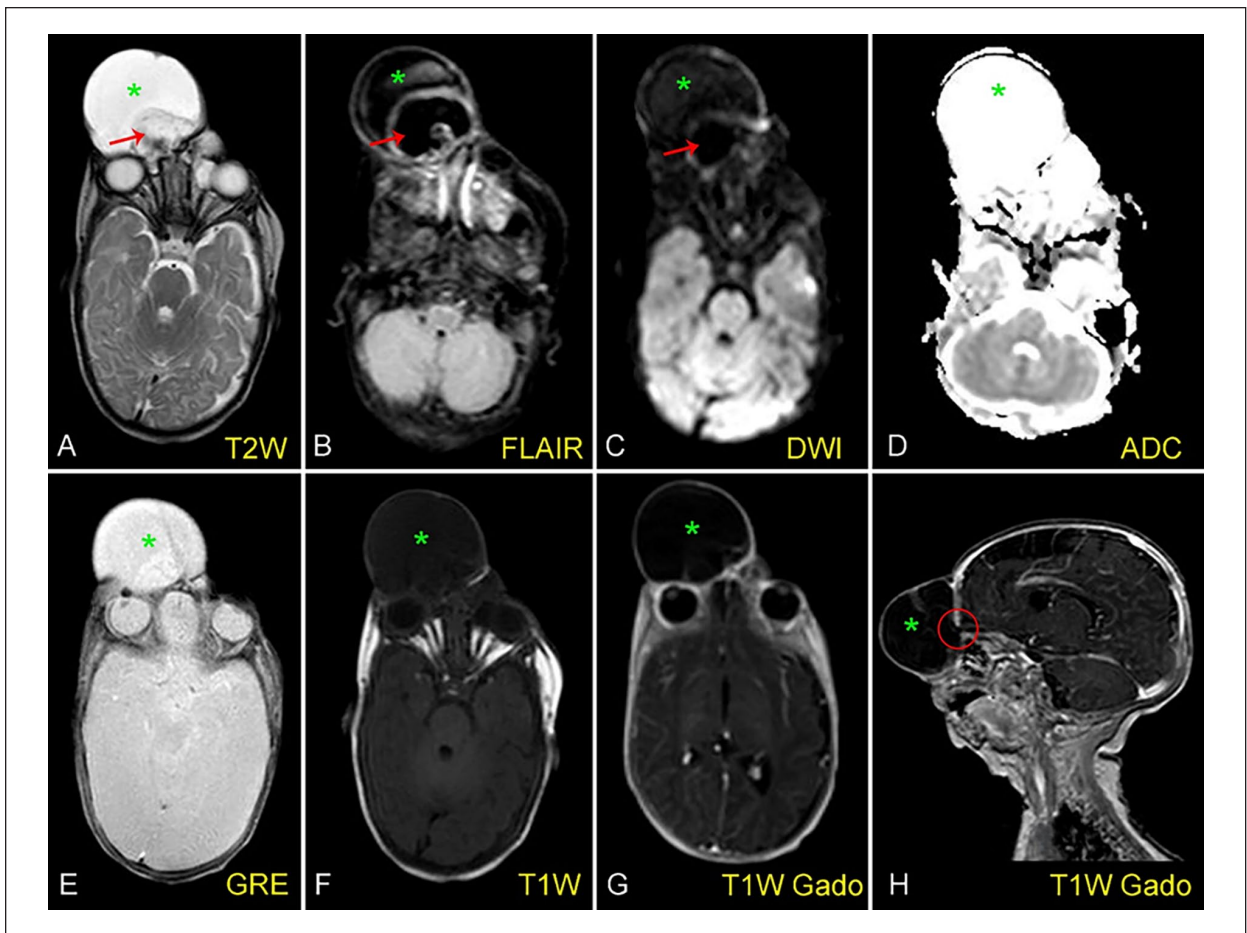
Axial T2W (A), FLAIR (B), DWI (C), ADC (D), T2* (E), T1W (F), T1W Gado (G), and sagittal T1W Gado (H) MR images show a cystic structure (asterisks) occupying most of the patient’s upper face. The signal of the mass content does not match the typical characteristics of pure cerebrospinal fluid and does not resemble brain tissue with noise components (arrows). Sagittal T1W Gado image shows a location that is likely to communicate with the cerebrospinal fluid space (circle).
